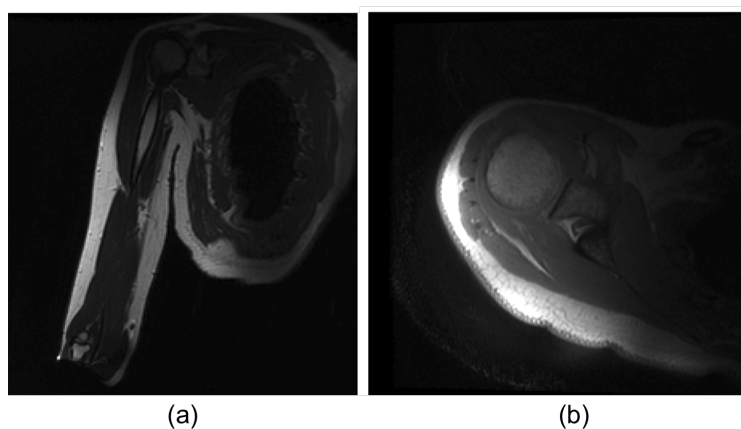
MRI scans of the shoulder (a) in the frontal plane and (b) in the transverse plane
